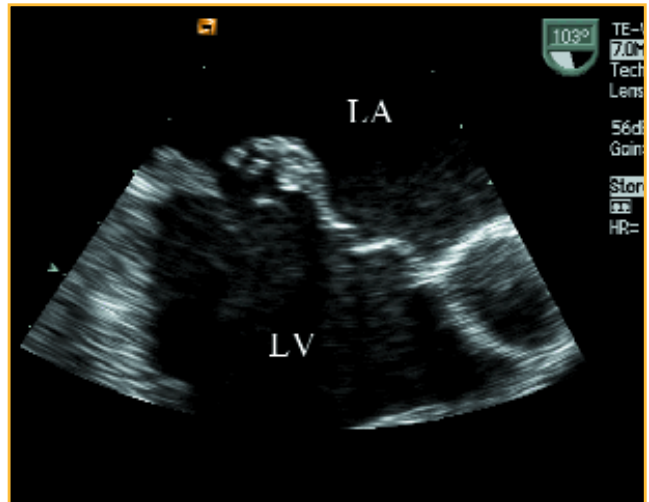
Severe prolapse with flail scallop and significant coaptation failure. Transoesophageal view.
